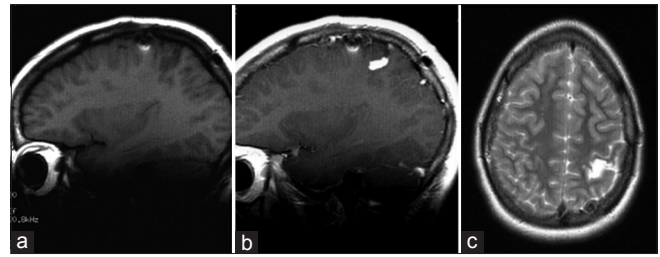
(a-c) Stereotactic sagittal T1, sag CET1, axial T2 MR images for Gamma Knife treatment planning demonstrates partial, solid contrast enhancement in the T2 hyperintense, residual DNT in the left postcentral gyrus (2002)
